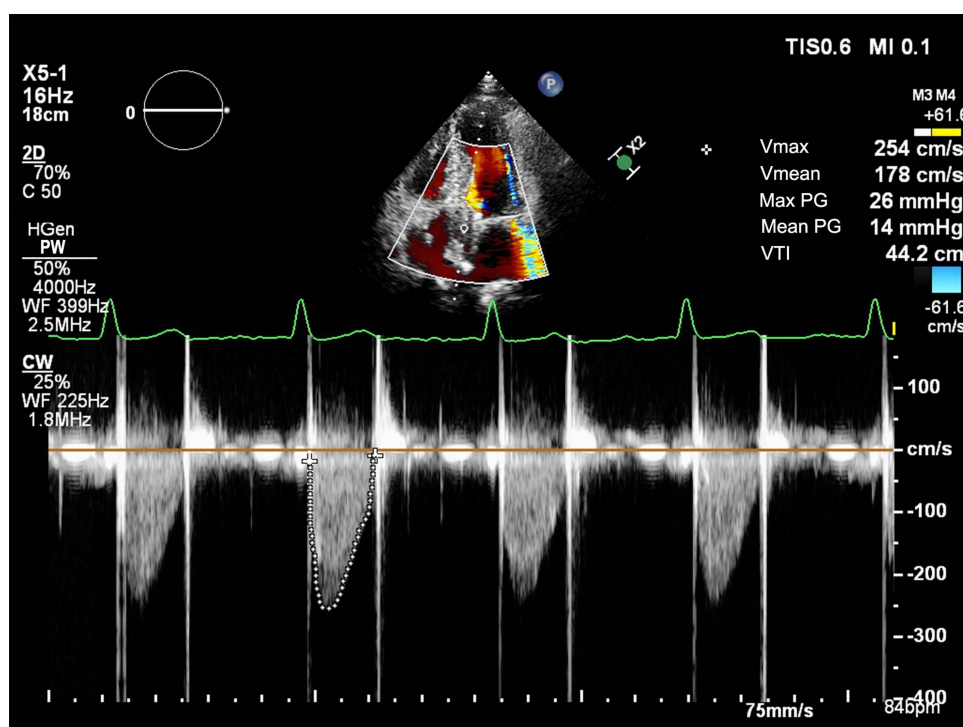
Transthoracic echocardiogram showed no vegetation attached to the aortic valve, and the forward flow rate of the mechanical valve after aortic mechanical valve replacement is normal.
